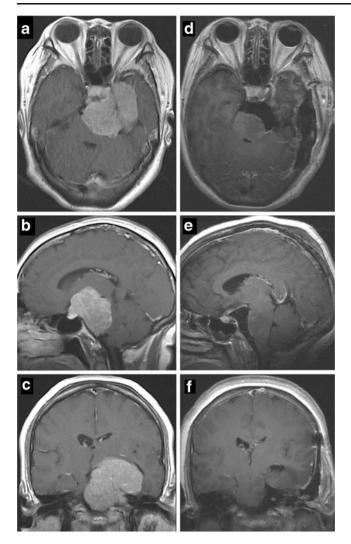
Case 1: pre- (a–c) and post-operative (d–f) magnetic resonance imaging. A female patient aged 53 years with a preoperative KPS score of 90. The tumor size was  $5.5 \times 5.9 \times 6.0$  cm. The patient underwent a presigmoid approach, and complete resection was achieved. Postoperatively, she suffered hoarseness, abnormal gait, and progression of left oculomotor dysfunction, with a KPS score of 70. After 84 months, she was able to perform household duties—with a most recent KPS score of 80. KPS, Karnofsky Performance Scale
